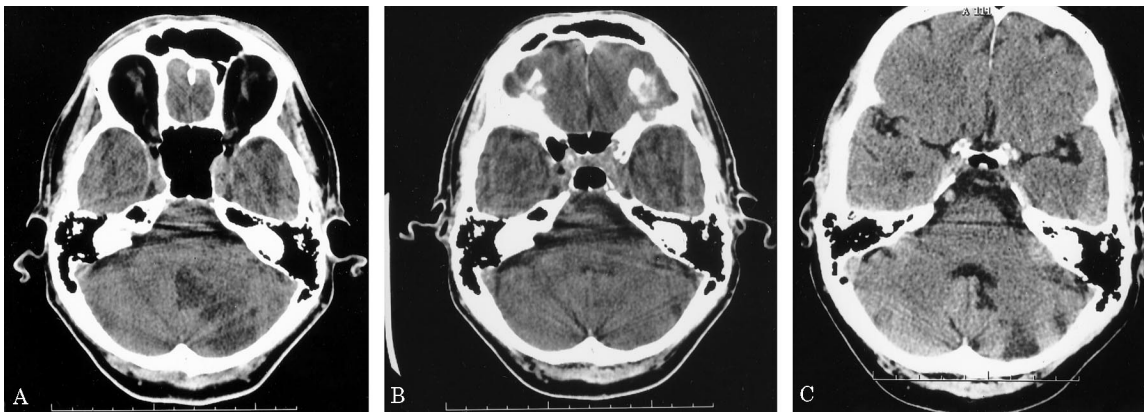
(A) Noncontrast CT scan of the head shows a triangular hypodensity in the territory of the lateral posterior inferior cerebellar artery compatible with a subacute infarct. (B) Follow-up noncontrast CT scan performed 11 days after the onset of the symptoms. The previously easily recognizable infarct is now not obvious. (C) CT scan performed 4 months later reveals an area of encephalomalacia in the same territory as the initial hypodensity.
